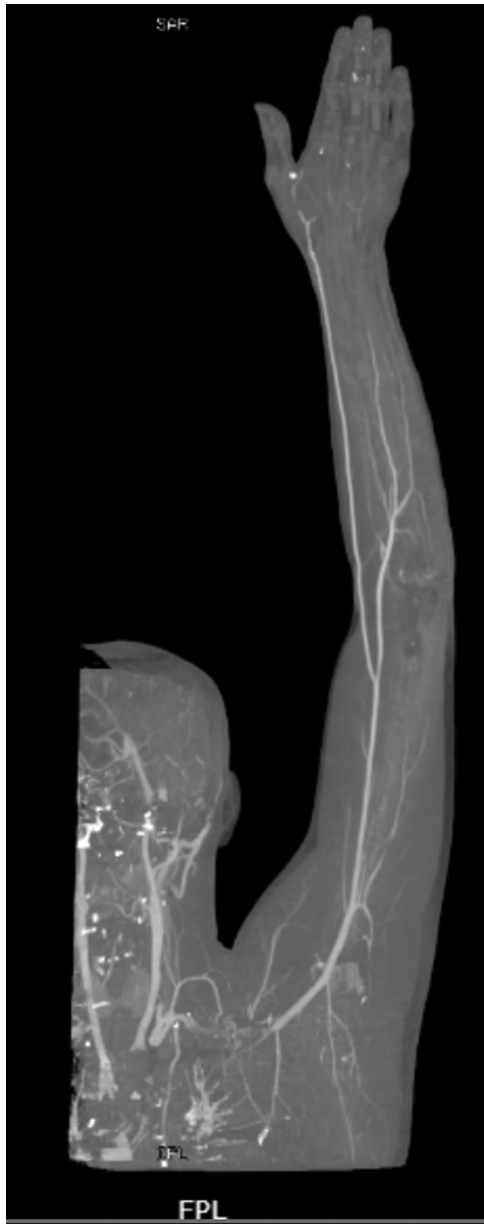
CT angiogram of Case 2 after 1 year showing stenosis of the right subclavian artery vascular graft.
